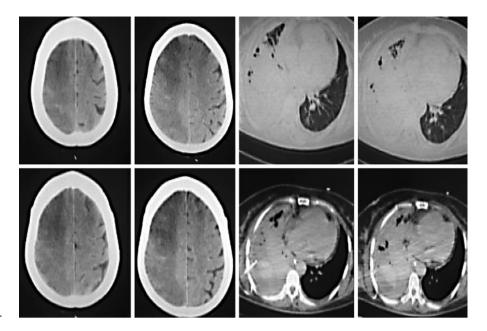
CT of the head and chest after 5 days.
